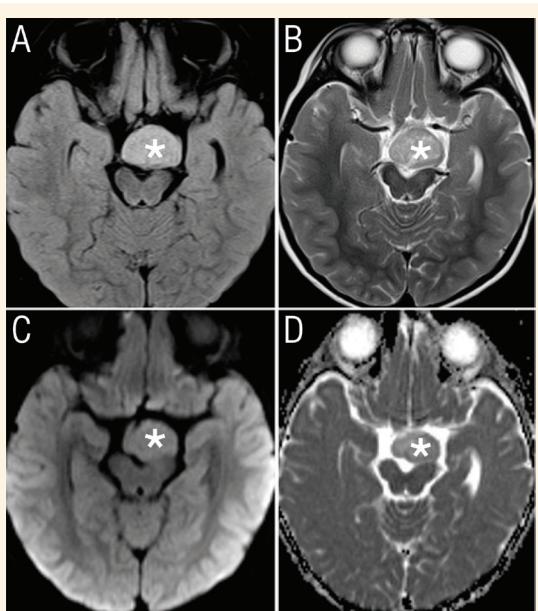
Magnetic resonance imaging (MRI) of the brain of a two-year and seven-month-old boy showing a hypothalamic (*tuber cinereum*) hamartoma (asterisk). It shows (A & B) hyperintense signal on fluid-attenuated inversion recovery and T2 MRIs. Axial diffusion-weighted MRI (C) and apparent diffusion coefficient map (D) images showing no evidence of diffusion restriction in this lesion.
